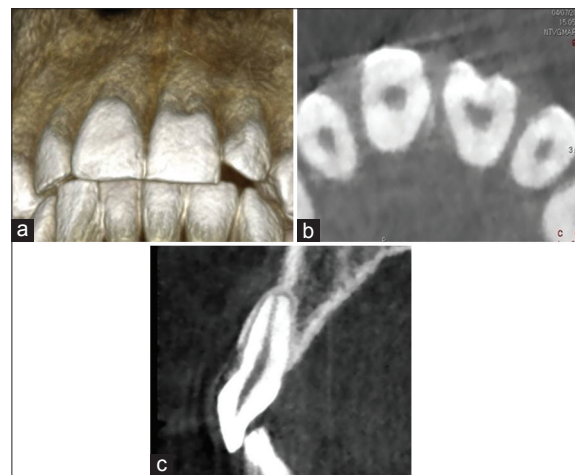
(a) Cone beam computed tomography of the left central incisor. Three-dimensional reconstruction. (b) Axial view showing the buccal invagination. (c) Orthogonal view of the 21, showing that invagination is limited to the cementum/dentine without pulpal communication
